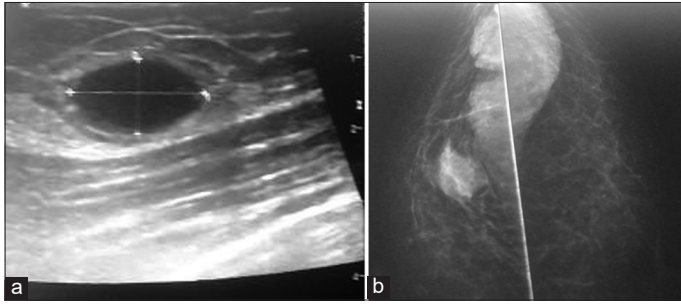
(a) Ultrasound of the breast showing regular oval opacity and (b) Mediolateral oblique mammography showing oval mass with a smooth and sharp margins
